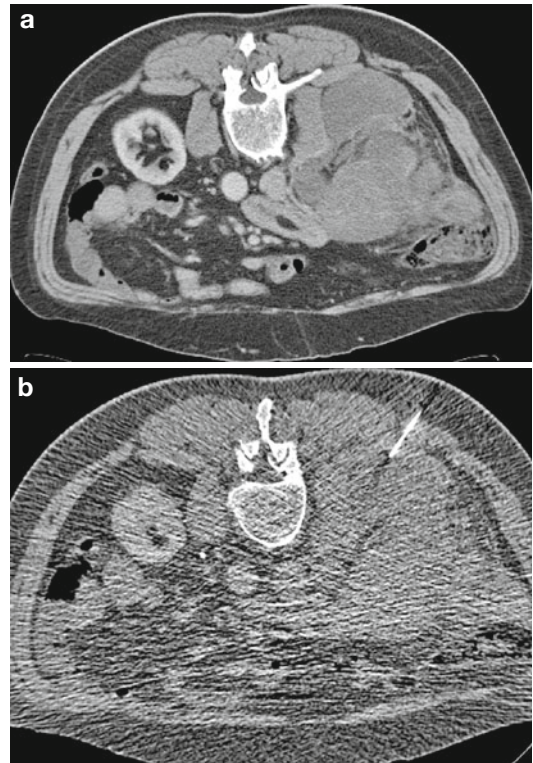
Patient (prone position) with suspect retroperitoneal mass encasing the right kidney (a). A right posterior approach was chosen for aspiration biopsy with a 19-G (10-cm) needle under CT-fluoroscopic guidance (b). Cytology revealed a lymphoma
